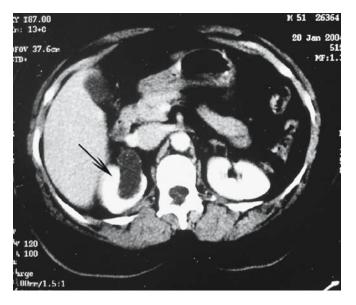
A CT urogram shows an obstructed upper moiety (arrow)
